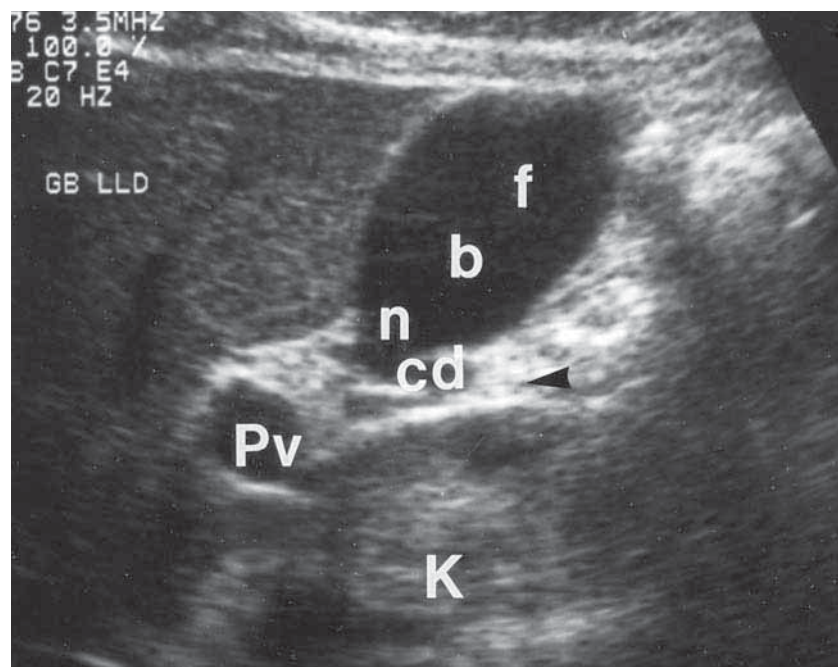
Parasagittal Ultrasound of Abdomen Demonstrating the Parts of the Gallbladder
